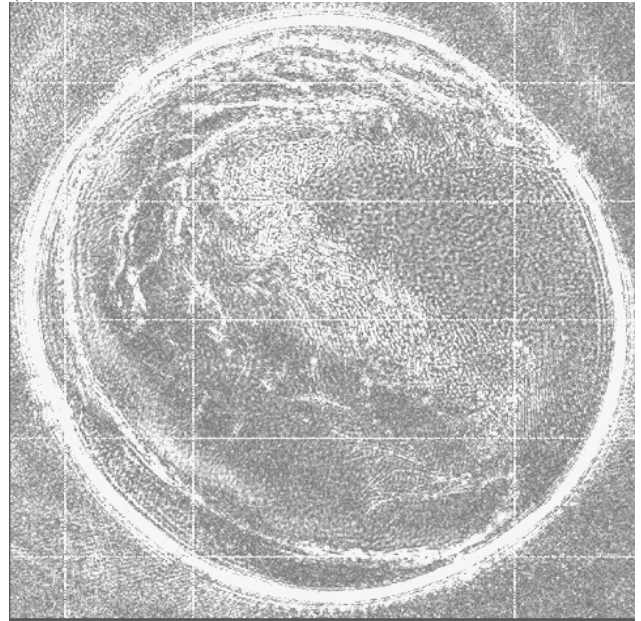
(a) US reflection image superimposed on the X-ray CT scan. The US reflection image has its grey scale inverted for better representation of the superposition. (b) US reflection image superimposed on the sound speed image.
